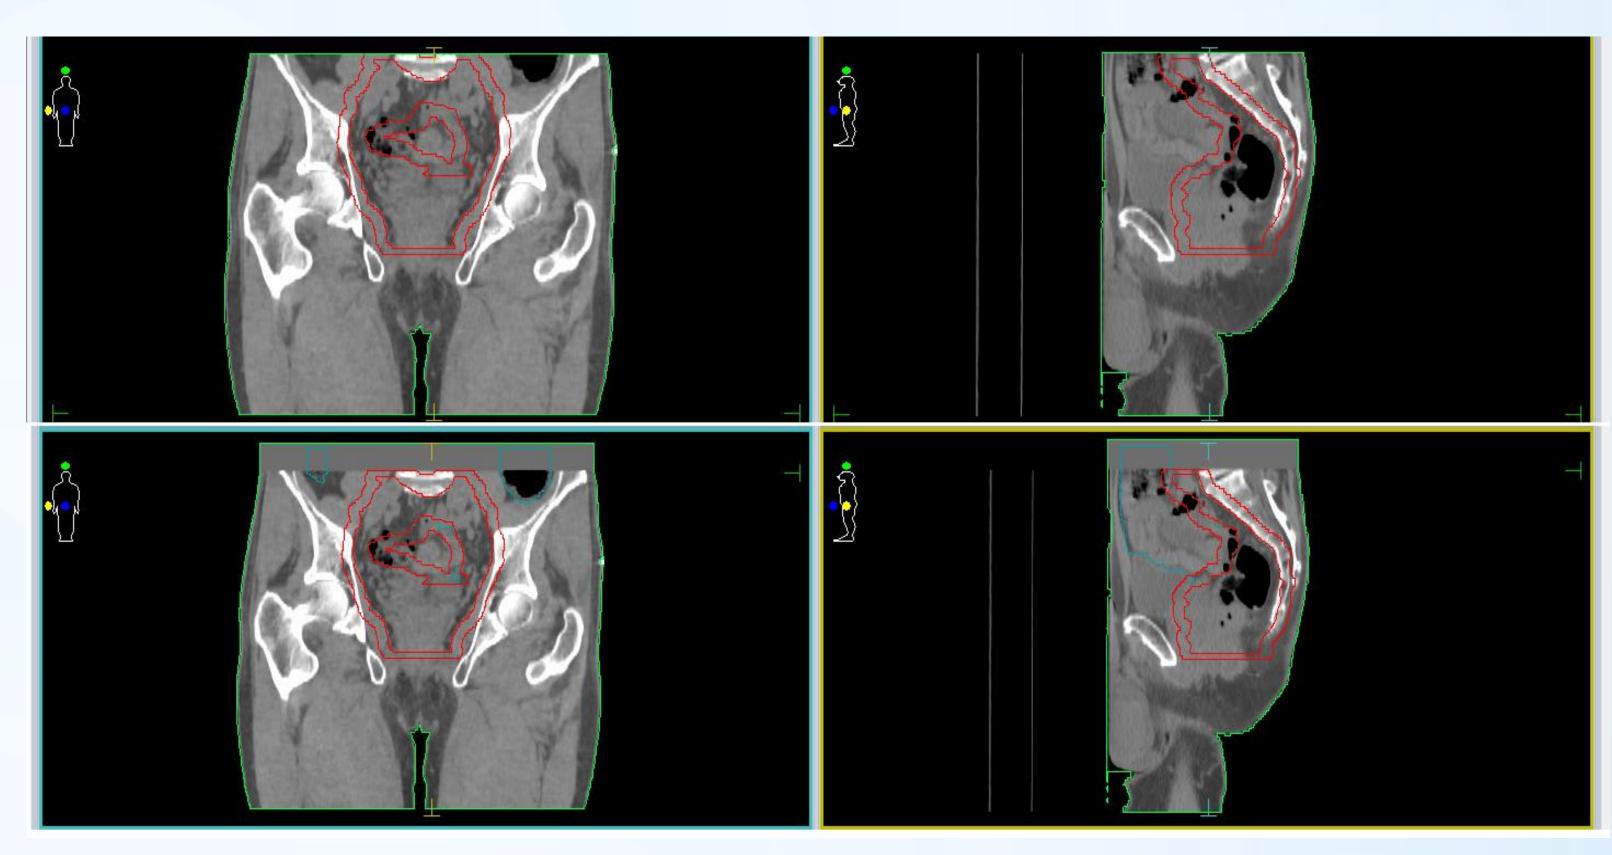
Example of artificially shortened(top images) and artificially extended(bottom images) CT series. The CT series in this example are extended as a copy of the last Body contour filled with HU for water.
